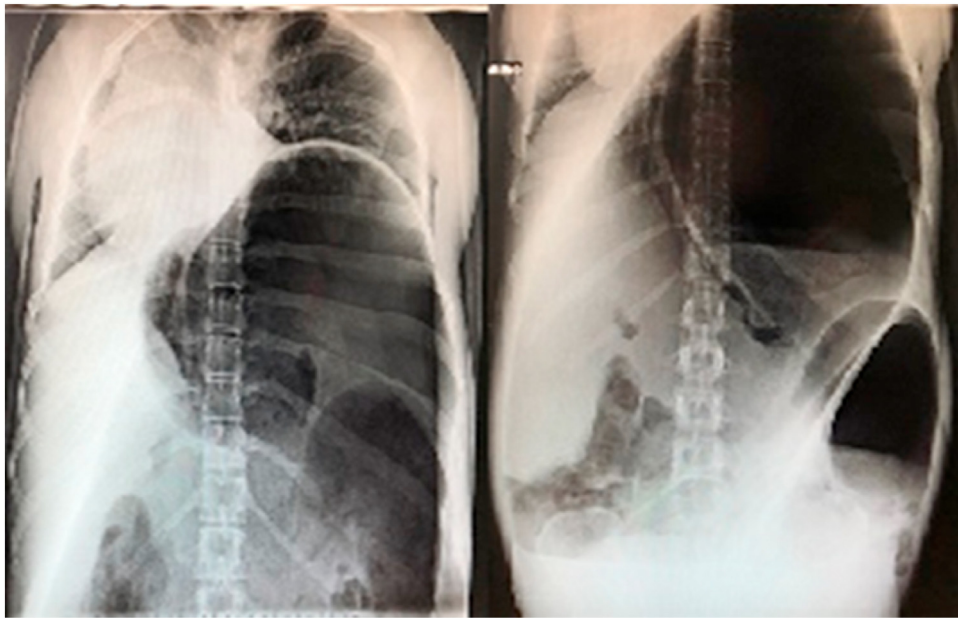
Abdomen X-rays showed colonic obstruction.
